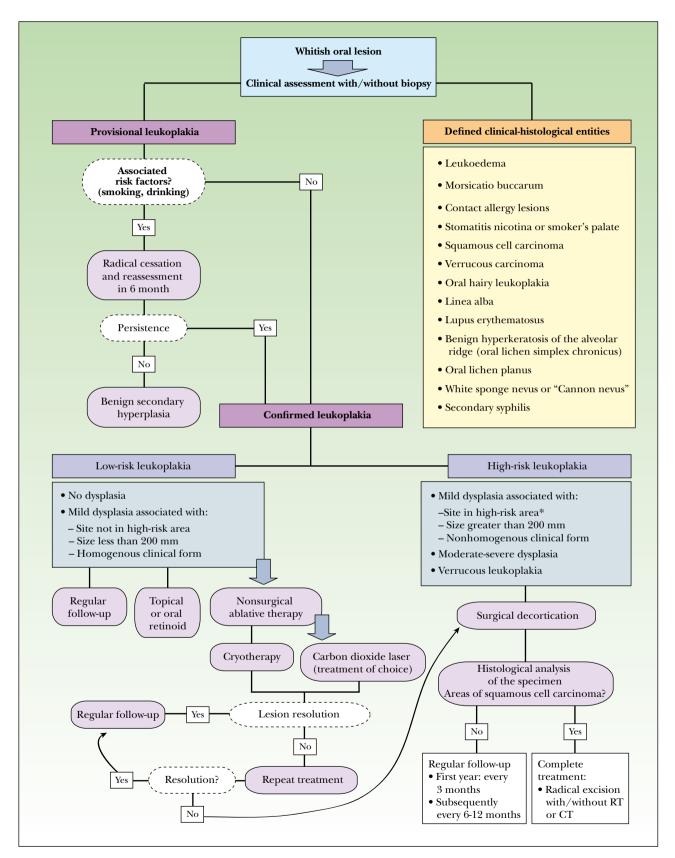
ADiagnostic-therapeutic algorithm for leukoplakia. CT indicates chemotherapy; RT, systemic radiotherapy. *Areas of high risk: floor of the mouth and ventrolateral area of the tongue.
